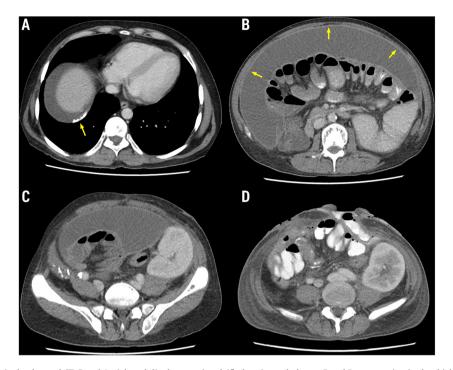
Axial view of an abdominal enhanced CT. Panel A, right subdiaphragmatic calcified peritoneal plaque. Panel B, progression in the thickening of the peritoneum with contrast enhancement, which englobes the intestinal loops and conditions a discrete small bowel distention with the presence of air-fluid levels, compatible with an initial obstructive process. Panel C, inferior view of the pelvis, with left kidney graft without alteration and atrophic changes of the first right kidney graft. Panel D, postsurgical changes of parietal peritoneum resection with an abdominal wall defect and oral contrast leak compatible with enterocutaneous fistula.
